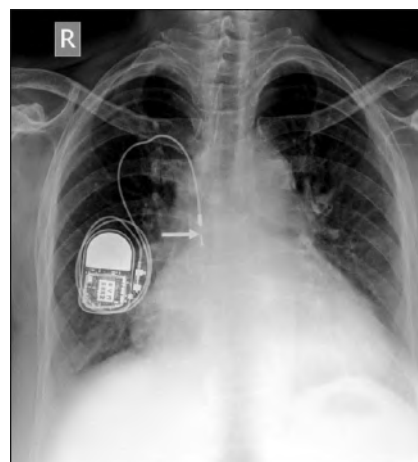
Chest radiograph shows recoil of the pacemaker lead with its tip in the superior vena cava (arrow). This is called Twiddler's syndrome.
